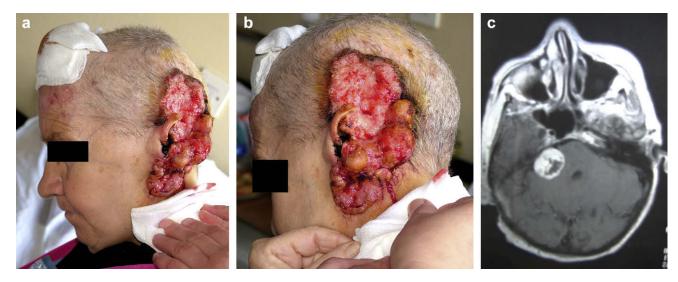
(a) and (b) An extensive, destructive and bleeding lesion of the scalp on the patient's left suboccipital, superior nuchal and retroauricular regions, including a total destruction of the left ear, was observed. (c) Magnetic resonance imaging revealed an extensive, destructive lesion of epicranial soft tissues of the left retroauricular and suboccipital regions, following full-thickness skull destruction and neoplastic invasion of the meninges with spreading into pontocerebellar angle.
